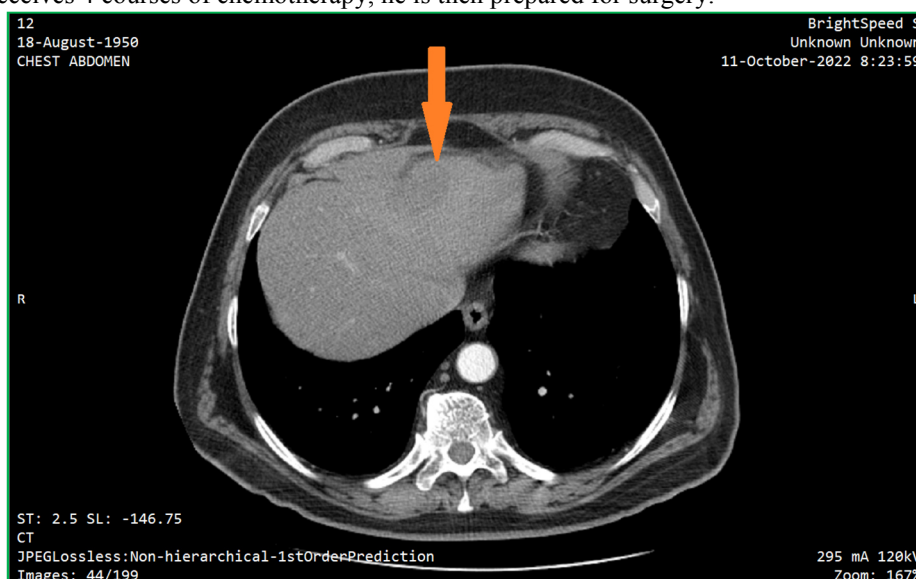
CT sequence showing a hypodense neoformation in segments II – III.
